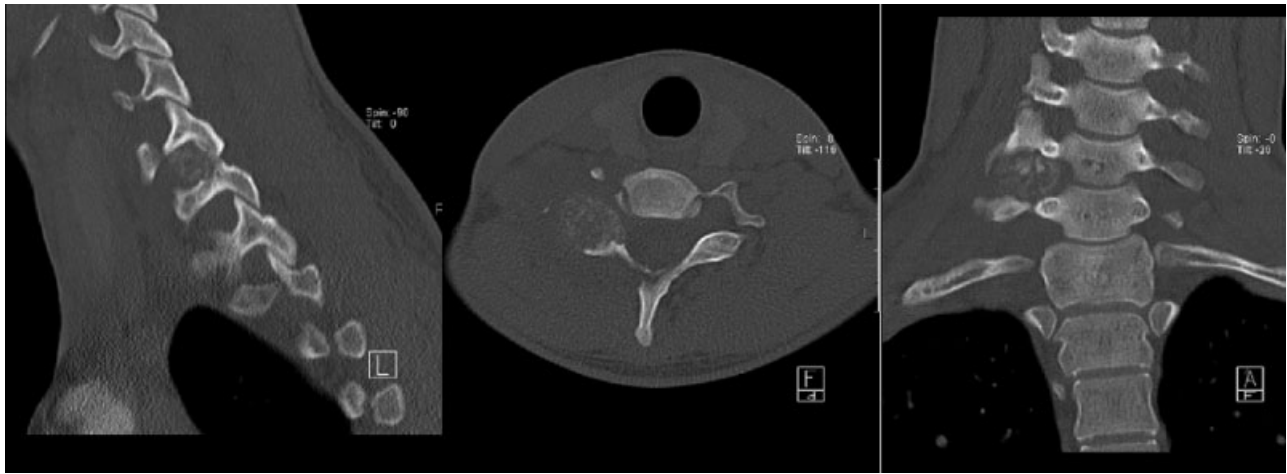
Cervical CT scan: mass lesion with well-defined limits involving facet joint and the right pedicle of C7.
